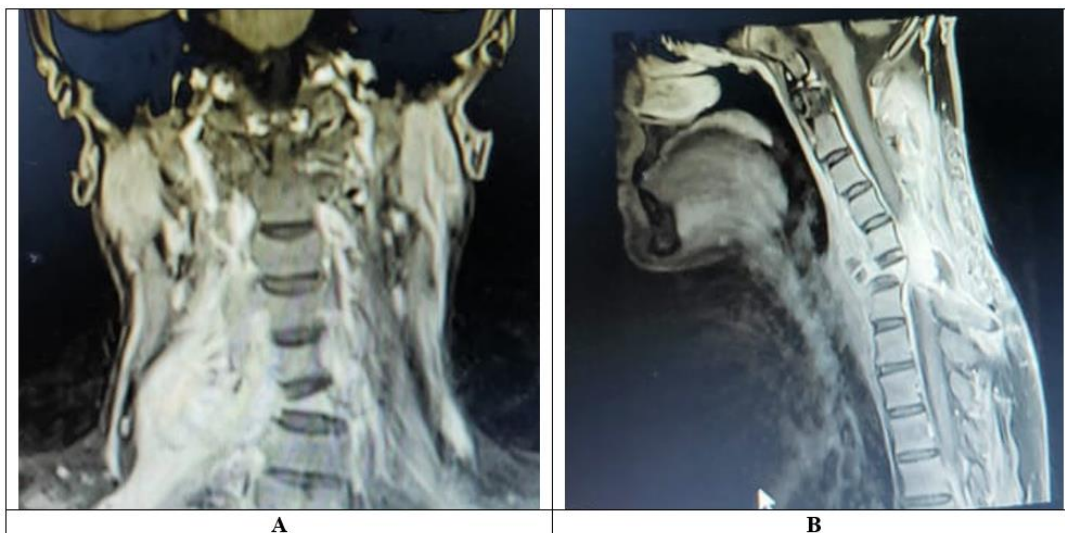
MRI of the cervix with contrast showed 3rd-degree compression above the C6 level and paravertebral abscess above the right side of the C4-7 level, extending into the epidural space along with canal stenosis and spinal nerve swelling; A Coronal View, B Sagittal View
